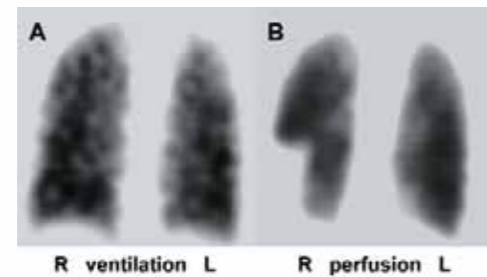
Coronal slices of a ventilation/perfusion lung scan (SPECT): while the ventilation (A) shows no substantial pathological changes, a large perfusion defect can be found in the lower lobe of the right lung (B). Diagnosis: mismatch defect caused by pulmonary embolism. R = right; L = left.
